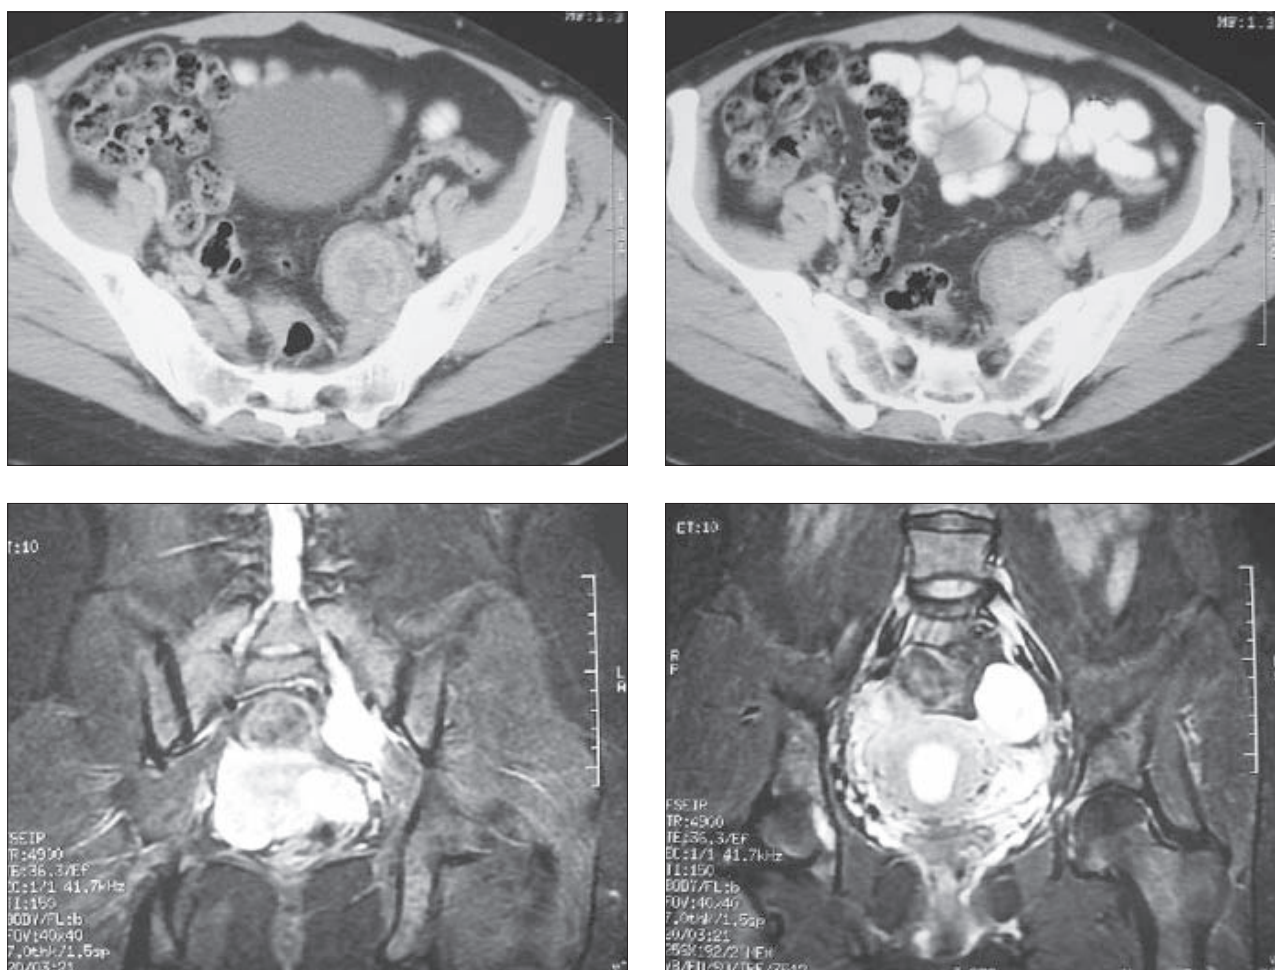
Presacral benign schwannoma of the pelvis in a 33-year-old woman (a) CT scan following contrast injection demonstrates central enhancement in the well-defined solid tumor in the left pre-sacral pelvic area. (b) Fat-saturated T2-weighted coronal MRI image shows the hyperintense tumor and its continuity with the neural fibers.
